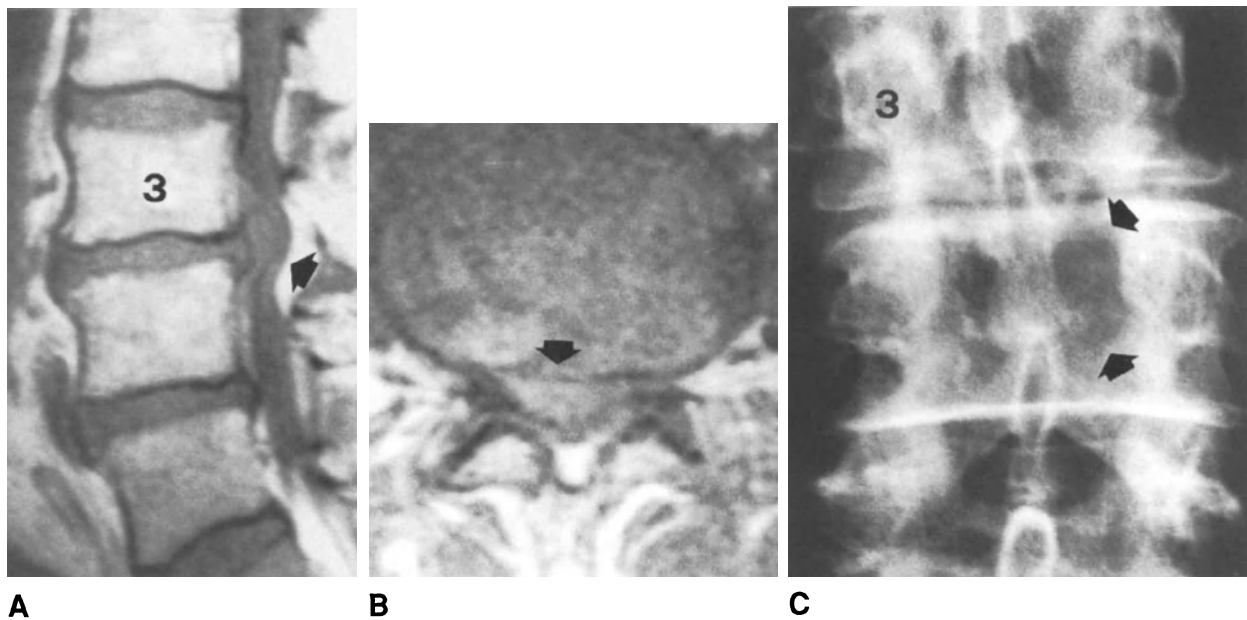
MR images and radiograph of a patient who had undergone surgical removal of right midline-paramedian disc herniation responsible for radicular pain prevalently on the left. (A) Spin-echo T1-weighted sagittal image showing a large extruded disc fragment at L3-L4 level (arrow). (B) Spin-echo T1-weighted axial scan showing a midline and right paramedian herniation and a narrow spinal canal (arrow). (C) Postoperative radiograph showing the laminotomy (arrows) through which the herniation was excised with complete resolution of symptoms.
